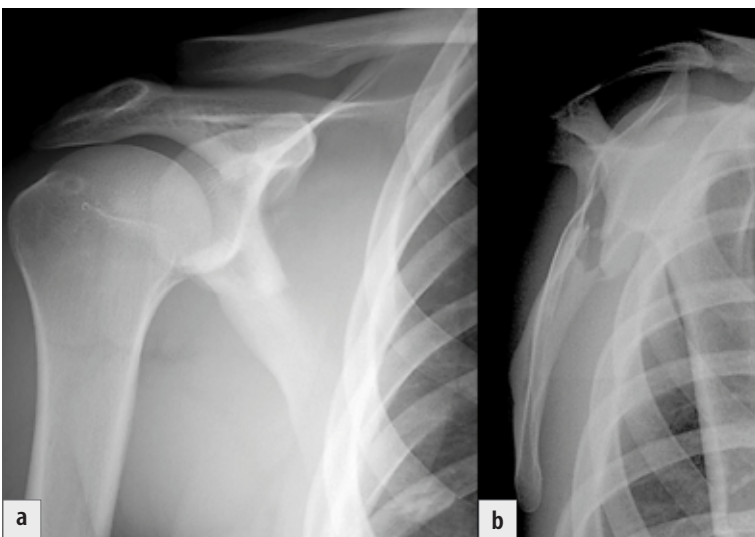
Radiograph of a stable fracture of the surgical neck of the scapula: a) anteroposterior view; b) lateral view.
